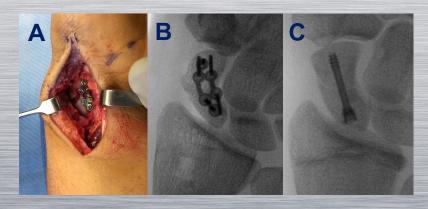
(A) intraoperative photograph of locking volar plate (Medartis, Basel). (B) Postoperative radiograph following fixation with locking volar plate. (C) Postoperative radiograph following headless compression screw fixation.
